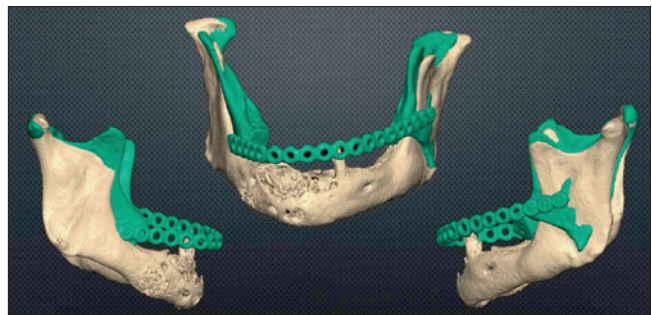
Superimposition of native mandible (yellow) and post-resection (green) CT-scan data showing mandibular rami displacement.
